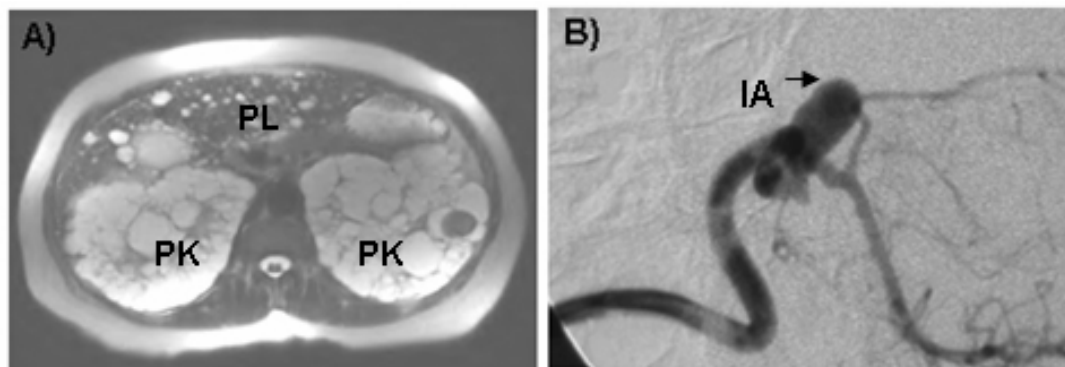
ADPKD phenotypes. ADPKD patient which MRI (A) shows polycystic kidneys (PK) and polycystic liver (PL), and which angiography (B) shows an intracranial aneurysm (IA). Pictures donated by Dr. Watnick.
